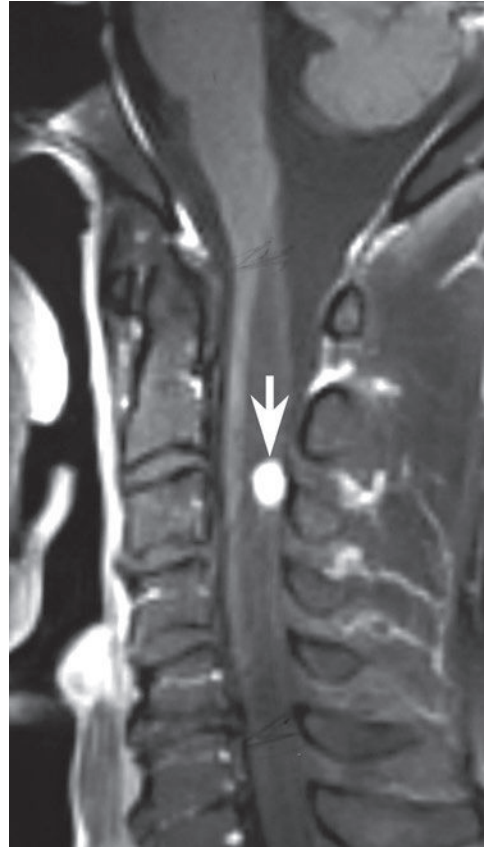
A sagittal postgadolinium fat-suppressed T1-weighted image of a cervical hemangioblastoma reveals a small, eccentrically located robustly enhancing tumor nodule (arrow) associated with a large cervicothoracic syrinx.[†]
